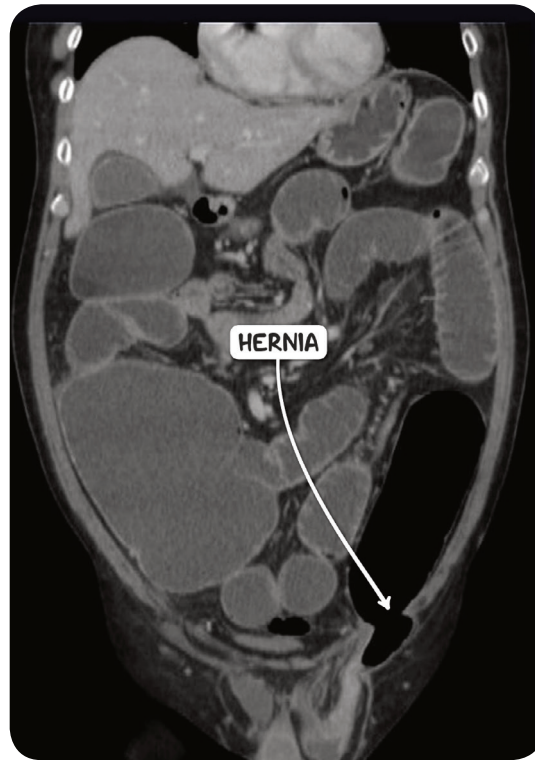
A CT scan in the coronal plane demonstrating an indirect inguinal hernia. The proximal bowel is dilated, indicating a strangulated hernia causing obstruction.
